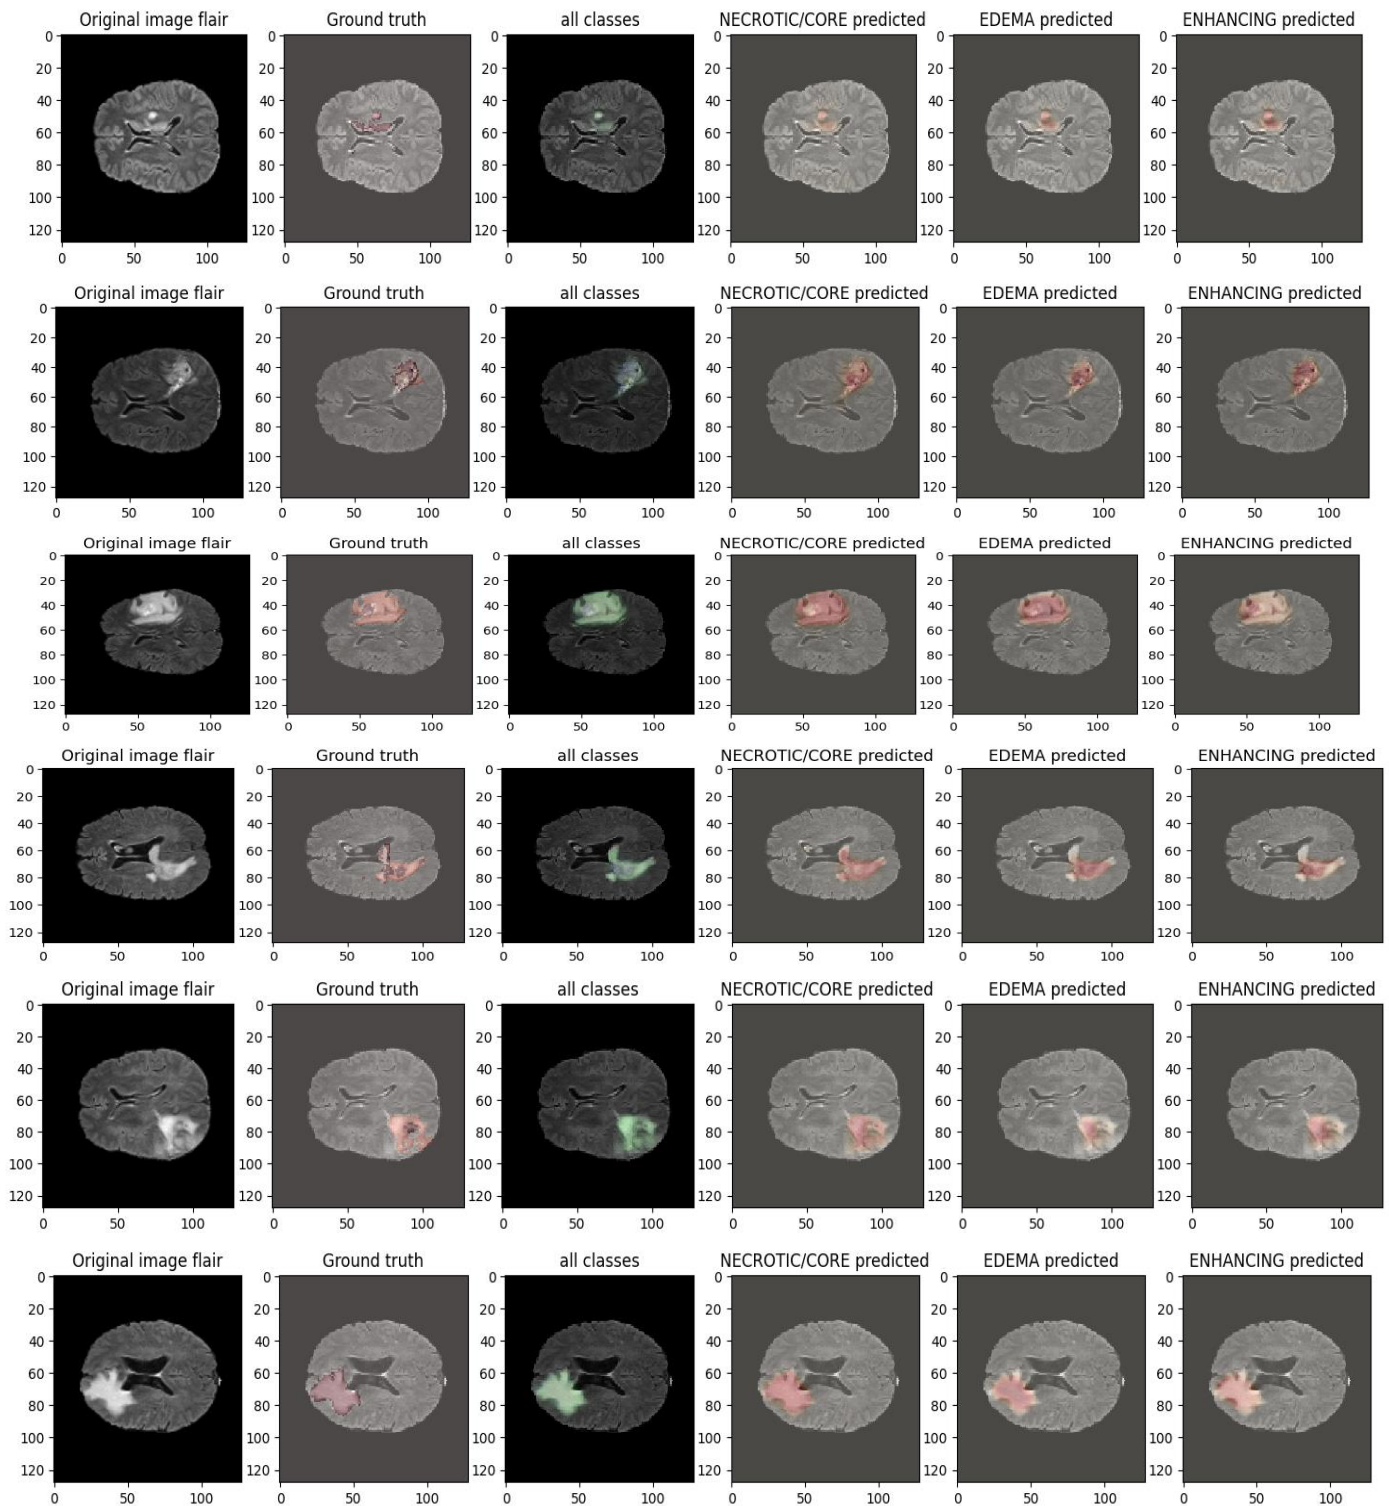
MRI segmentation visualization for multiple test cases.
